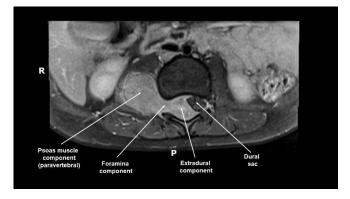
Spine MRI in axial plane, T1, gadolinium contrasted, lumbar level, exhibiting the NB and its paravertebral, extradural and foraminal components. Personal archive of Marcius Benigno Marques dos Santos, MD.
